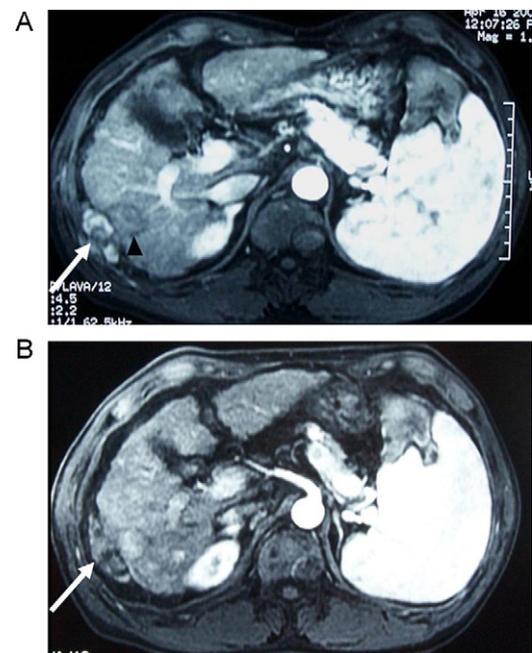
A 54-year-old man with elongated configuration of needle tract seeding after percutaneous microwave ablation of subcapsular hepatocellular carcinoma, who was previously performed biopsy for two insertions. (A) Transverse contrast-enhanced MRI image shows hypointensity subcapsular ablation zone for 17-mm diameter HCC lesion (arrowhead) in early venous phase. A heterogeneous hyperintensity 23-mm diameter seeding nodule (arrow) is showed attached to the peritoneum 11 months after MWA. (B) Contrast-enhanced MRI shows hypointensity MWA zone (arrow) for seeding lesion in arterial phase.
